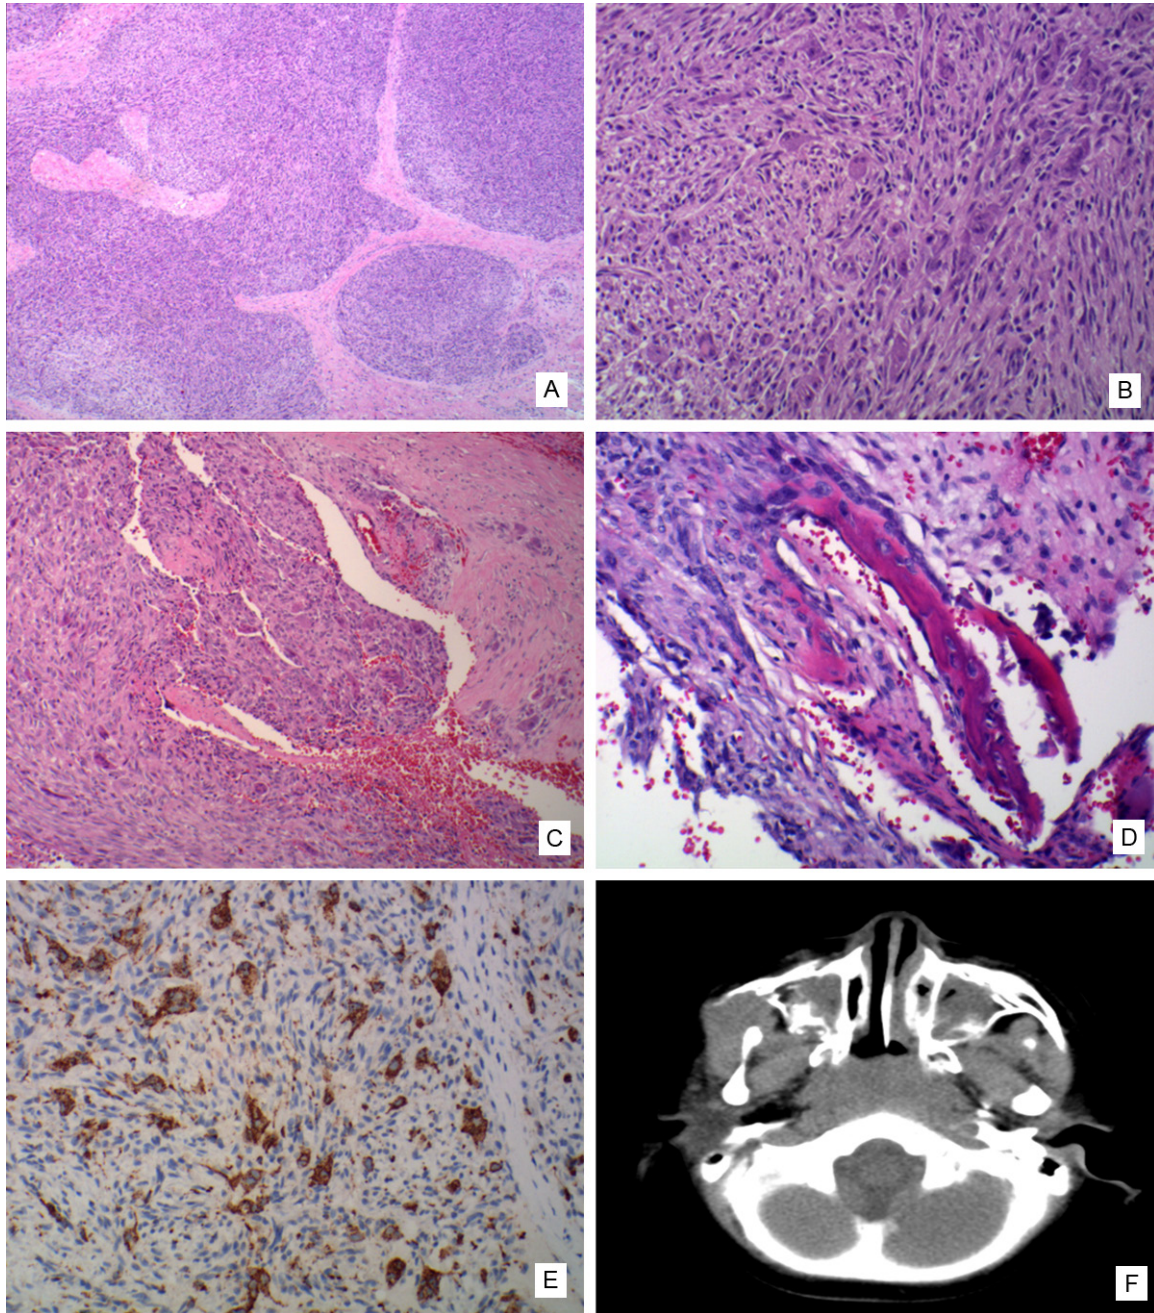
A. Low-power view of plexiform fibrohistiocytic tumor, the tumor displayed multiple nodules of plexiform distribution. B. High-power view of the tumor nodules with mononuclear histiocyte-like cells, multinucleated osteoclast-like cells and spindle fibroblast-like cells. C. The tumor with intravascular tumor thrombus. D. The bone tissue invasion of the tumor. E. Expression of CD68 in histiocyte-like cells and multinucleated osteoclast-like cells. F. The CT revealed on the right side of the front of masseter with low density, compression of adjacent cheekbones.
